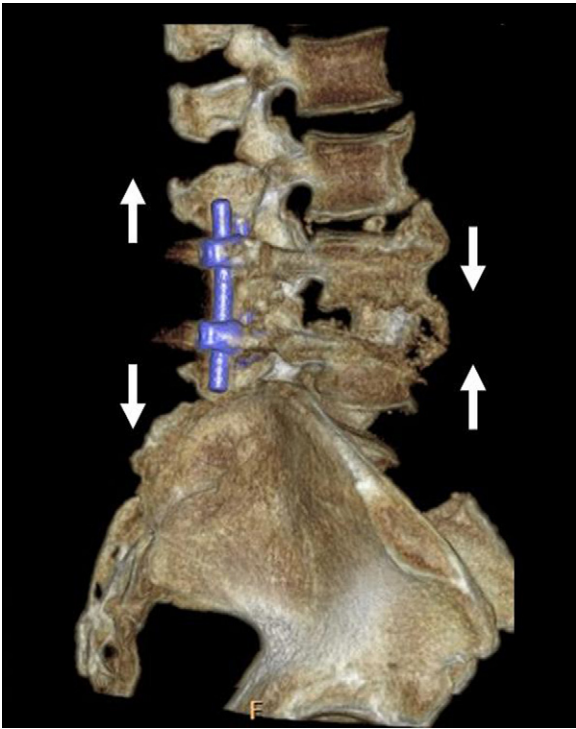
3D CT-scan, lateral view reconstruction. A 45-year-old patient with L5–S1 infectious spondylodiscitis treated with disc remotion, curettage of the proximal face of the above and below vertebral bodies, interbody tricortical autograft, and posterior pedicular screw instrumentation. The interbody tricortical autograft is under compression, and the posterior pedicular screw system provides a tension band principle. The autograft for this use cannot be cancellous bone, but a strong tricortical one.
